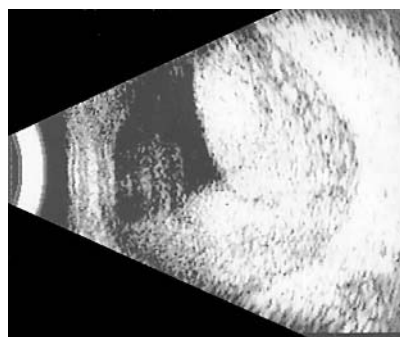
The findings of B-mode ultrasound examination. A massive haemorrhage in the choroids is present.
